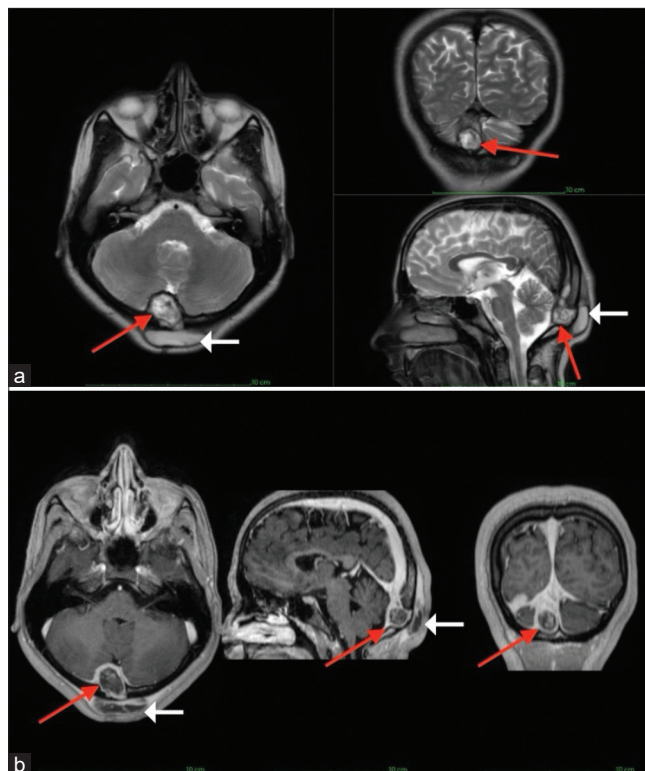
Contrast magnetic resonance imaging of the brain at the level of the largest collection (red arrows) seen in the right occipital region, predominantly in the midline and on the right side. The largest collection measured 1.9 × 1.2 × 1.4 cm, extending through the occipital bone (white arrows) into the subcutaneous fat. The lesion was heterogeneously hypointense on T1, (a) hyperintense in T2 and (b) showed peripheral rim enhancement on postcontrast images. The adjacent brain parenchyma showed no alteration in signal intensity characteristics and no edema.
